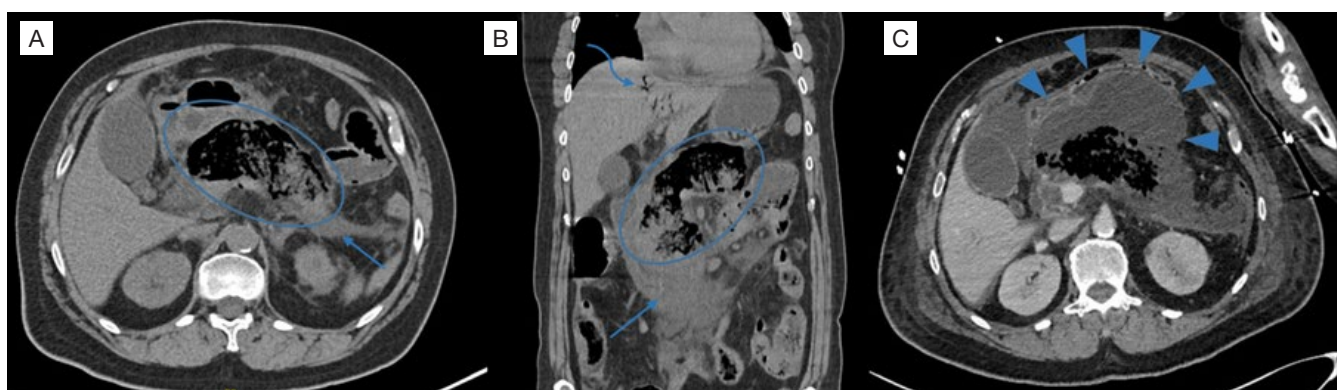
Axial (A) and coronal (B) non-enhanced computed tomography (CT) images acquired at the time of admission. Axial contrast-enhanced venous phase CT image (C) acquired one week after.
